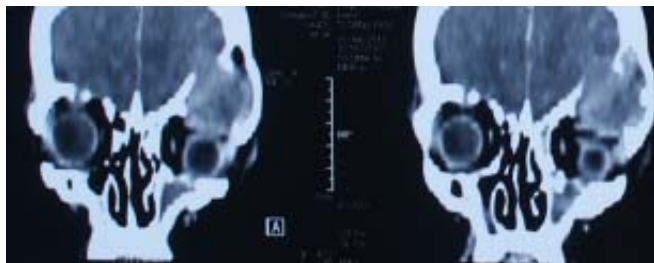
Acute frontal sinusitis CT exam showing the destruction of the posterior wall of the left frontal sinus
